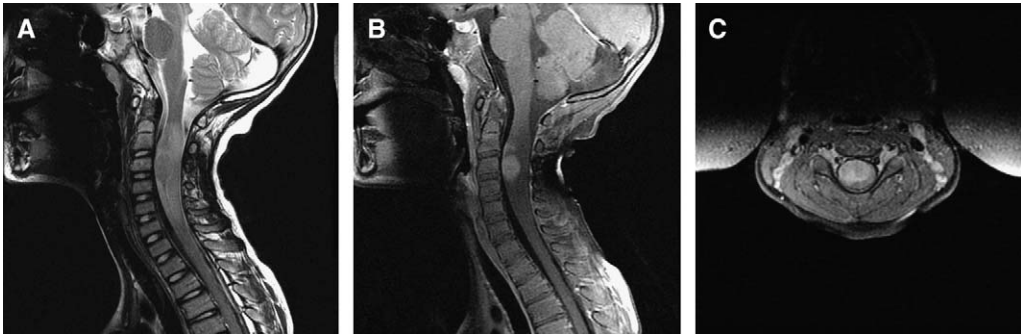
Astrocytoma. Sagittal T2-weighted (A), post contrast sagittal T2-weighted (B), and post contrast sagittal T1-weighted images (C) images of the cervical spine demonstrate a ventral intramedullary mass centered at the C3 vertebral body level. There is a moderate amount of tumor-related edema, which extends superiorly to the level of the medulla and inferiorly to the C6 level as seen on sagittal T2-weighted images. The mass demonstrates homogeneous enhancement.
